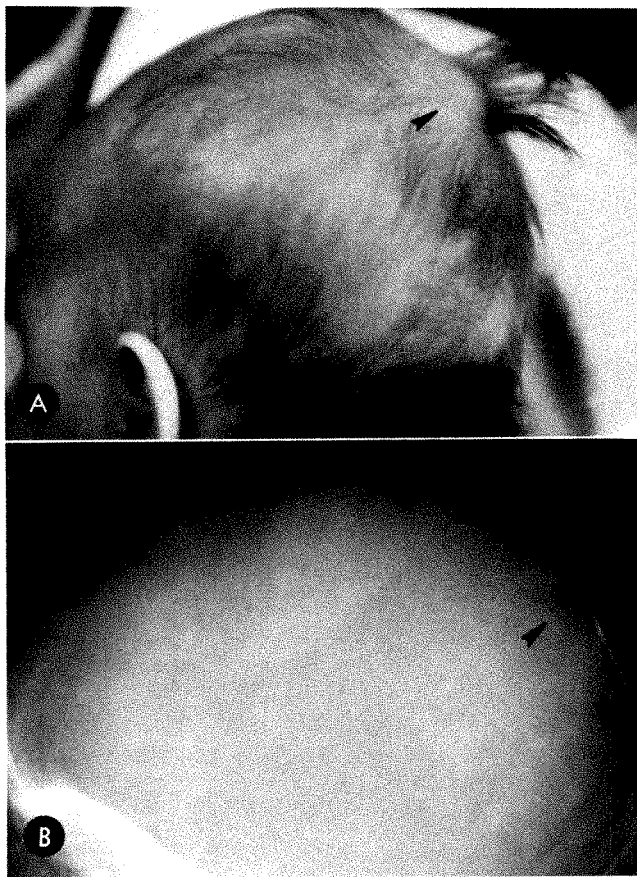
A, 2-month-old infant with congenital soft tissue mass in posterior interparietal region, with excessive growth of hair on mass (arrow). B, Lateral roentgenogram of same patient demonstrating underlying skull defect (arrow). A ventriculogram showed absence of the corpus callosum, without hydrocephalus or communication with the epicranial lesion. Diagnosis: epicranial arachnoid cyst.
